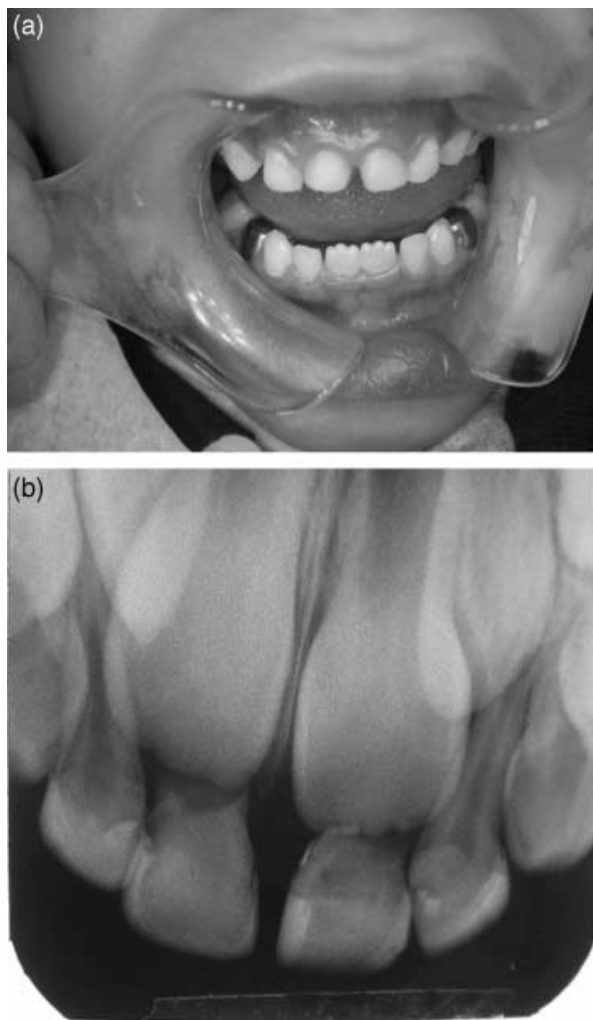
(a) Clinical appearance of four strip crowns at follow-up after 52 months. (b) Radiographic examination of the same crowns at follow-up after 52 months.
